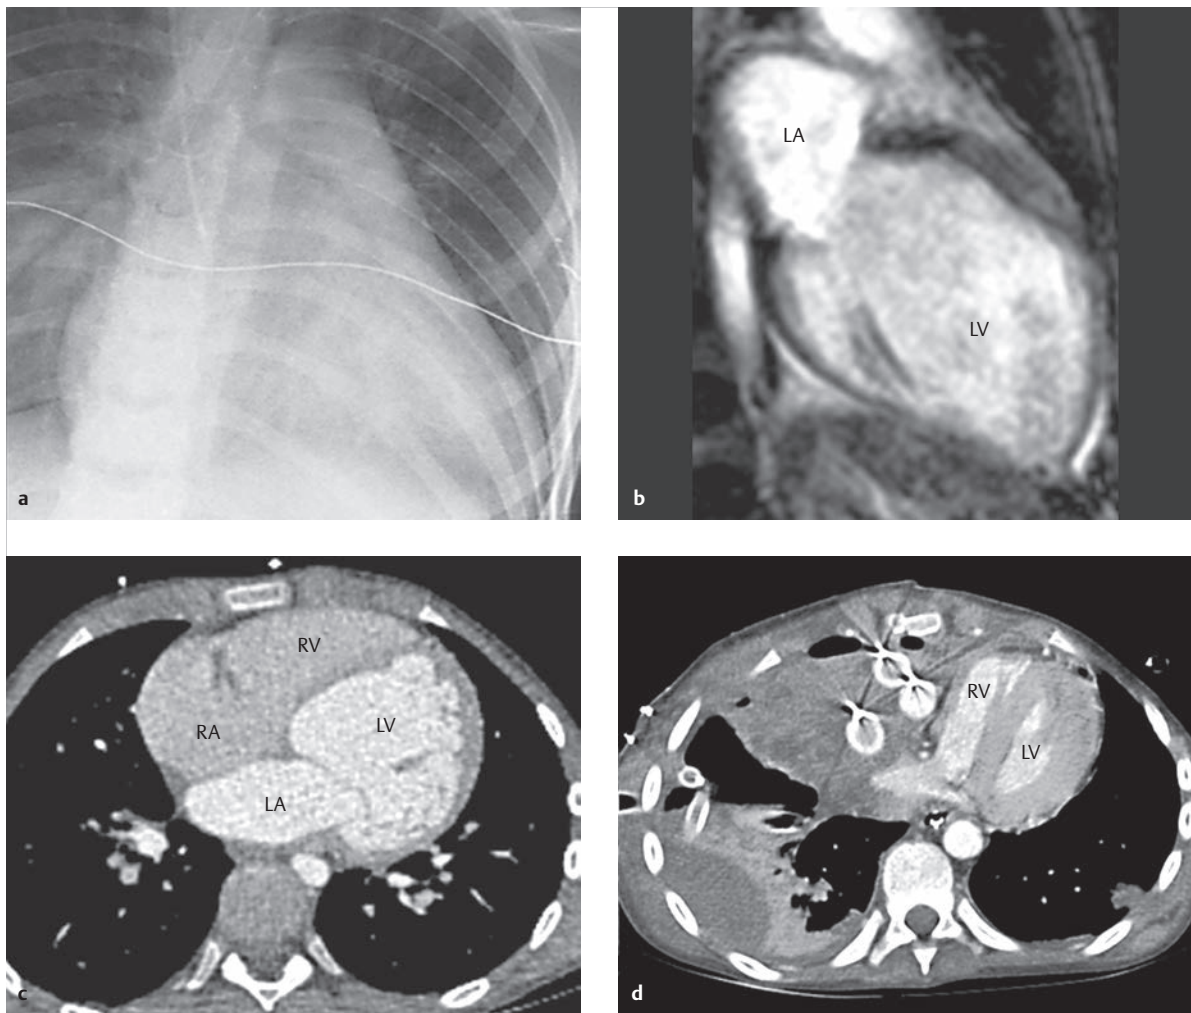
Foudroyant acute myocarditis after influenza infection. Thirteen-year-old boy. Significantly enlarged left ventricle with significantly limited left ventricular function, MRI (left ventricular ejection fraction of 14%, left ventricular EDV of 256 ml or 208 ml/m², global relative enhancement of 6.0 [standard: less than 4.5], edema ratio of 2.1 [standard: less than 2]). As the patient's clinical condition worsened, a left ventricular assist device (LVAD) was implanted, resulting in ventricular size reduction in the follow-up MDCT by means of pressure reduction (d).
